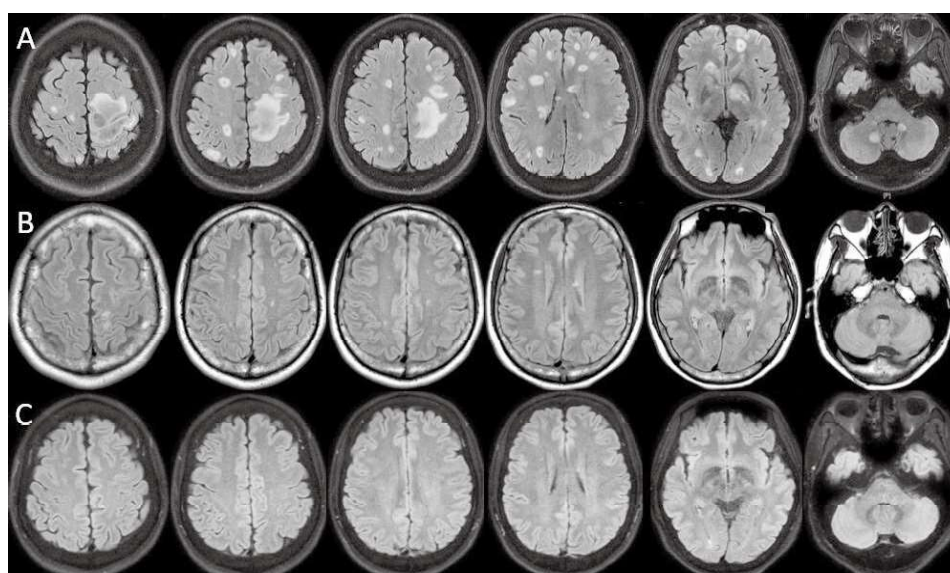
Brain magnetic resonance angiography (MRA) T2/FLAIR; (A) Day 32 of hospitalization; brain MRA revealed multiple ring-enhanced lesions with central necrosis and adjacent white matter edema at the bilateral cerebral hemispheres, left thalamus, midbrain, pons, and bilateral cerebellum; (B) Day 85 of hospitalization; brain MRA revealed significant improvement in terms of abscess size and number; (C) 3 months after the completion of treatment; brain MRA revealed complete remission of the preexisting brain abscesses.
